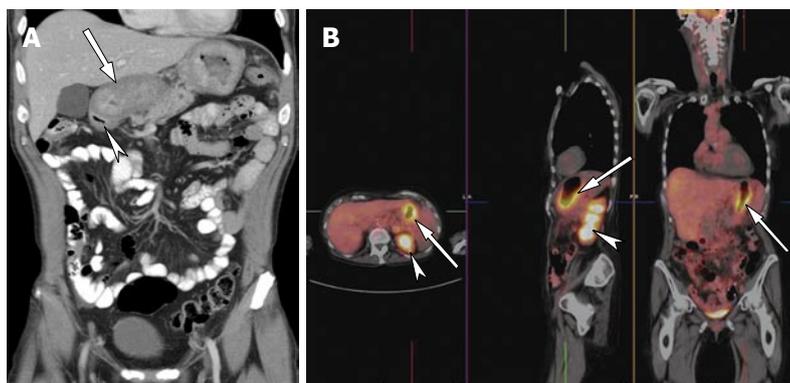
Sixty-nine years old male with dyspepsia. A: Coronal reformat showed diffuse thickening of the gastric wall (arrow). The duodenal cap was normal (arrowhead); B: Fused PET-CT images showed hypermetabolic activity of the gastric wall indicating cancer. No other foci of abnormal uptake were identified. Note the normal increased activity in the renal collecting systems (arrowheads) due to excretion of radiopharmaceutical.
